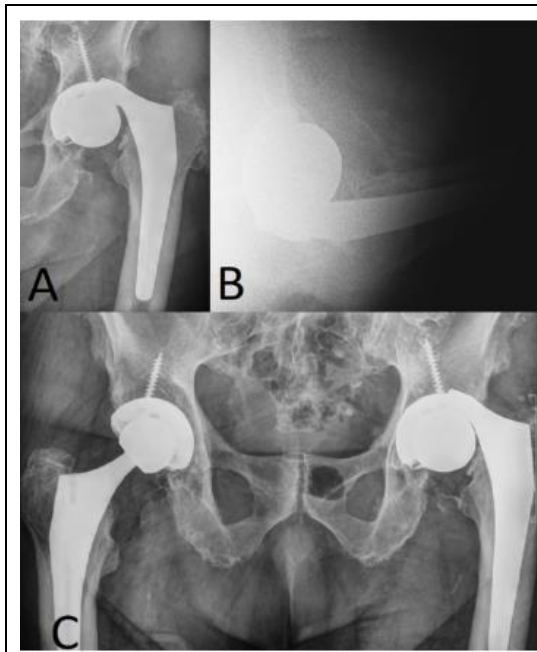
1A-1C Radiographs (Case 1). Preoperative anteroposterior left hip (A), lateral left hip (B), and anteroposterior pelvic (C) radiographs demonstrating gross trunnion failure with dissociation at the femoral head-neck junction.
